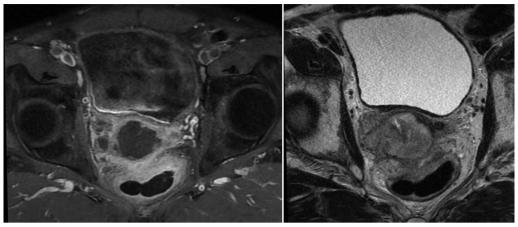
MRI of the pelvis revealing extensive peripheral zone collection in the right prostate lobe synchronous with right seminal vesicle collection
